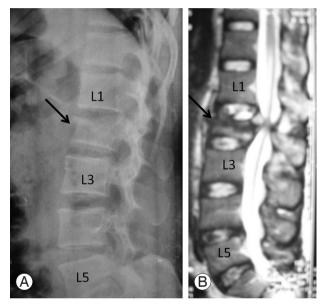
Radiograph (A) and magnetic resonance imaging (B) of the lumbar spine showing fracture of the L2 vertebra (arrow).
